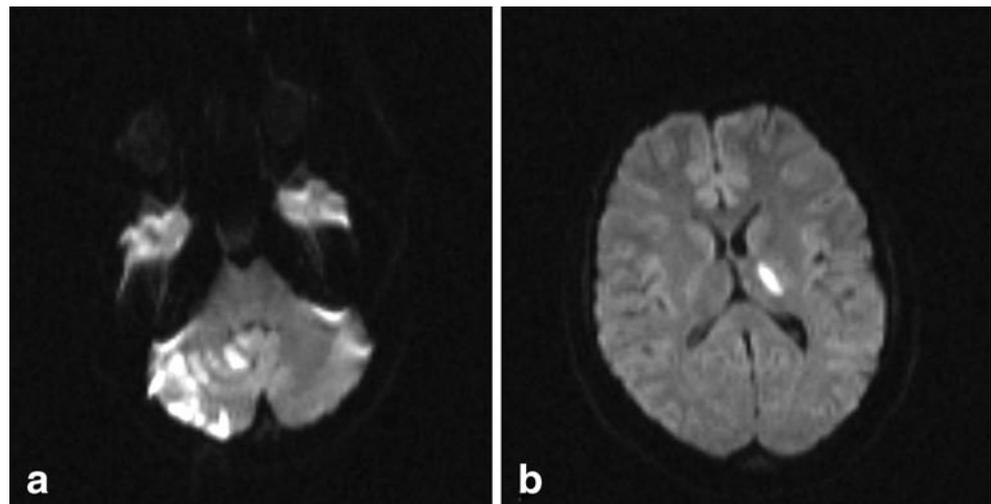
MRI, diffusion-weighted imaging (DWI) obtained after onset of focal symptoms revealing multiple hyperintense ischemic lesions in the right cerebellar hemisphere (a) and the left thalamus and posterior limb of the internal capsule (b). These lesions were identified as acute ischemias in corresponding apparent diffusion coefficient (*ADC*) maps (not shown)
